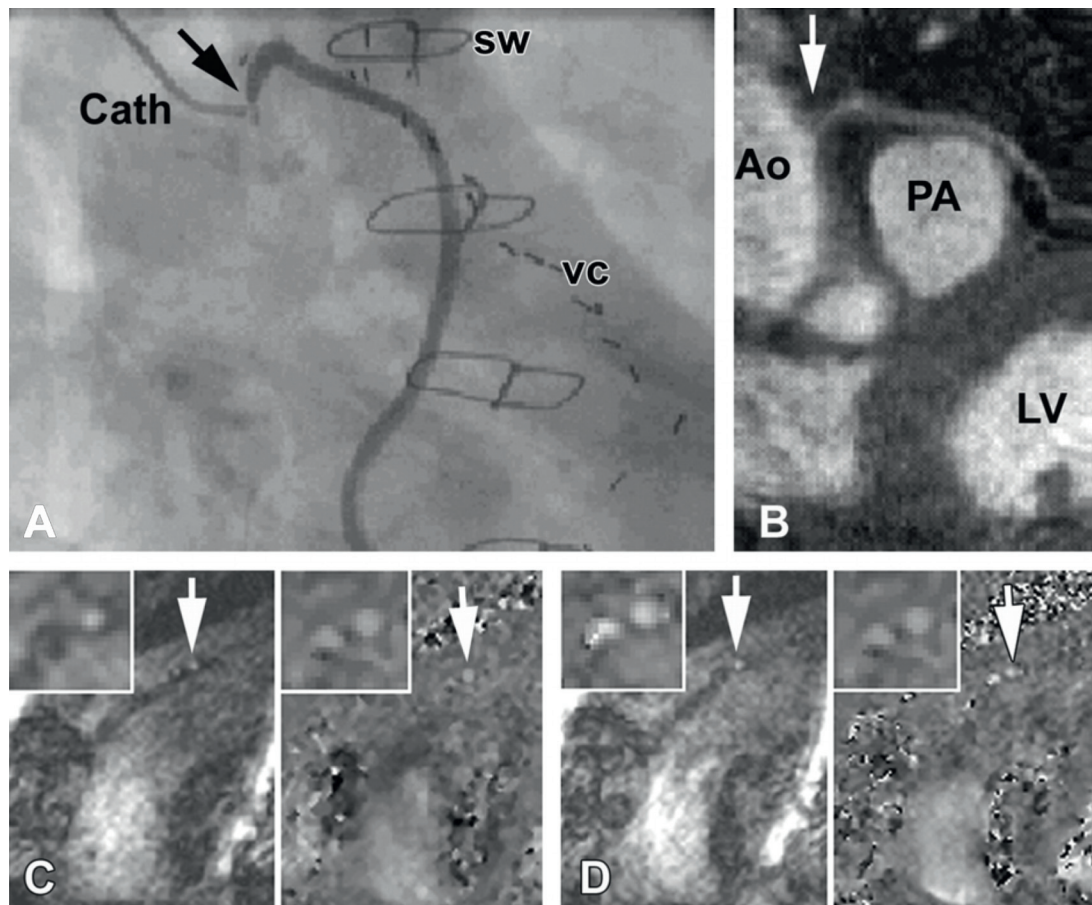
Results of an MR imaging examination of grafts. Panel A shows an ICA of a sequential vein graft to the LCx in a 61-year-old man with a 74% origin stenosis (arrow) in the graft. In panel B, a multiplanar reconstruction of navigator-gated three-dimensional MR angiographic data confirms the origin stenosis (arrow). In panels C and D oblique sagittal flow MR images are shown obtained at baseline (Panel C) and during stress (Panel D). Images on the left are modulus images with anatomic information; images on the right are phase images with velocity information. A detail of the graft cross section is depicted in the upper left corner of each image. Arrows indicate cross section of the graft depicted in Panels A and B. In addition and more anterior to a cross section of the stenotic vein graft, the cross section of a LIMA graft to the LAD can be seen. Reprinted with permission from reference 30. Ao: ascending aorta; Cath: catheter; LAD: left anterior descending coronary artery; LCx: left circumflex coronary artery; LIMA: left internal mammary artery; LV: left ventricle; PA: pulmonary artery; sw: sternal wire; vc: vascular clip
